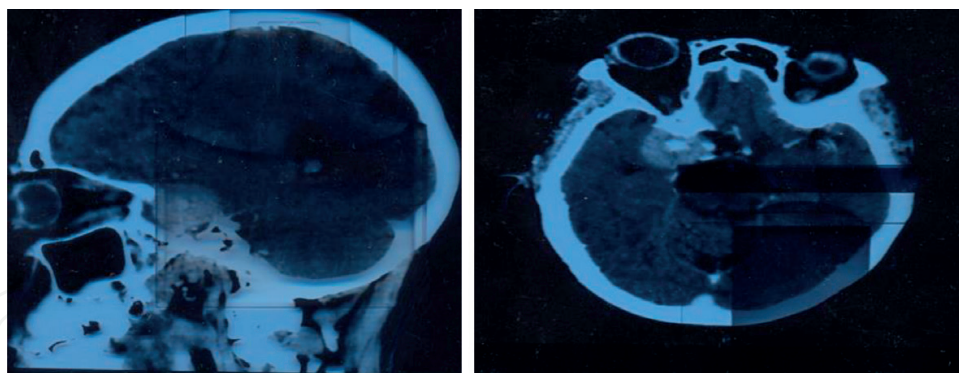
CT scan showing tuberculum sellae meningioma with areas of hyperostosis.
